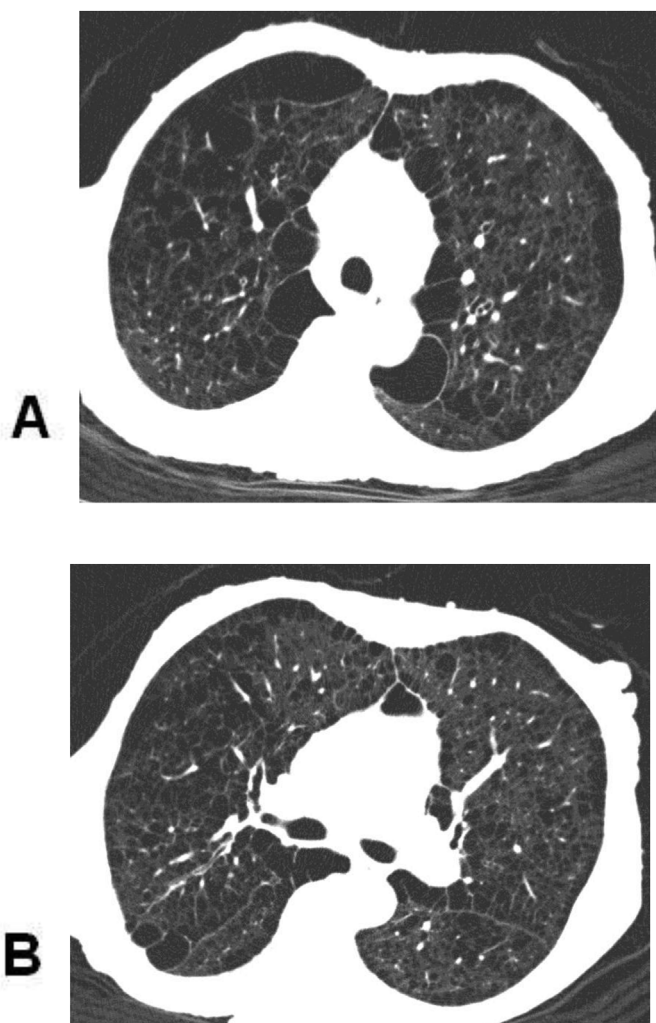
A 64-year-old female smoker with neurofibromatosis type 1. Axial high-resolution CT images obtained with lung window settings at the levels of the upper lobes (a) and the tracheal bifurcation (b) show numerous large subpleural bullae and emphysema with predominance in the upper lobes. Note also bilateral, variably sized, thin-walled cysts distributed without peripheral-central predominance. Multiple cutaneous neurofibromas are visible in the thoracic wall.
